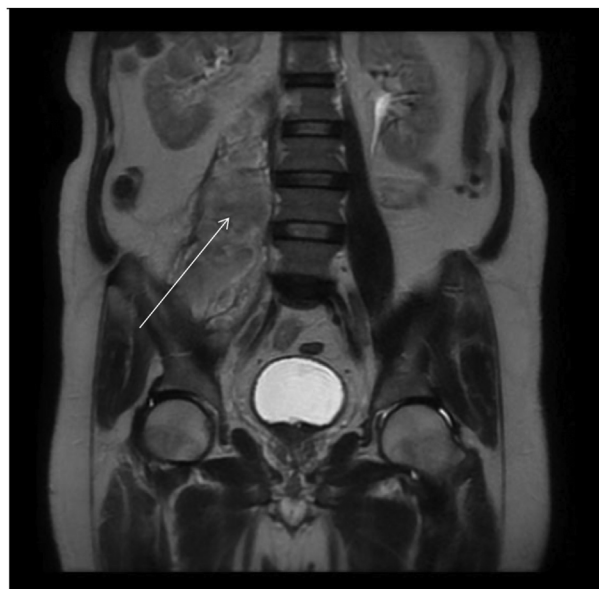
Coronal view of a pelvic MRI with the white arrow pointing to the large intramuscular fluid collection.
